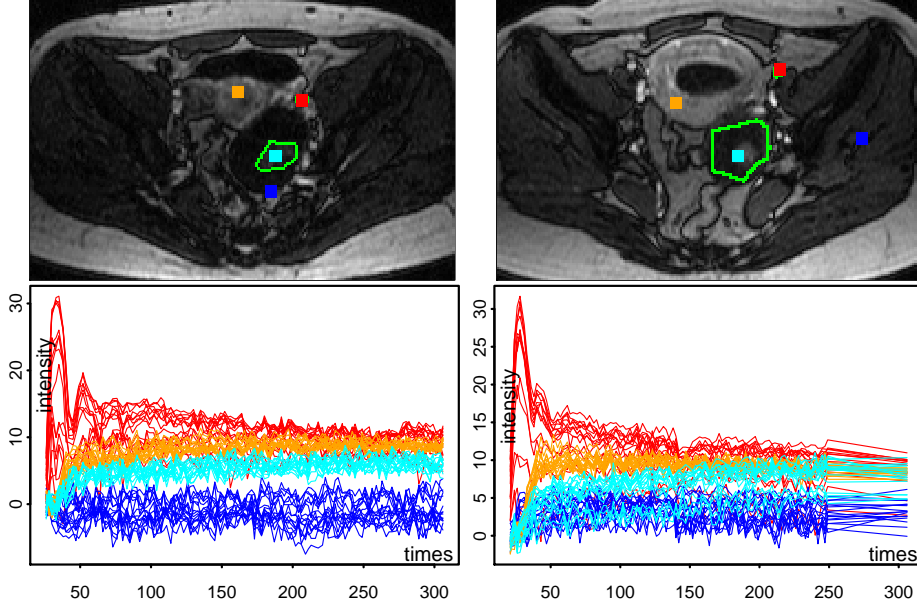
Two DCE-MRI image sequences on female pelvis with ovarian tumors - each column shows one sequence. Up: image obtained at time  $t_{30}$  (after arterial phase) with the tumor ROI (green) together with four 4x4 squared neighborhoods (red, cyan, orange and blue), the red ones covering the iliac artery identified by the radiologist. Bottom (with corresponding colors): the sets of 16 time enhancement curves,  $I^x(t_j)$ , observed in the four squares after variance stabilization using  $a = 0.45$ .
